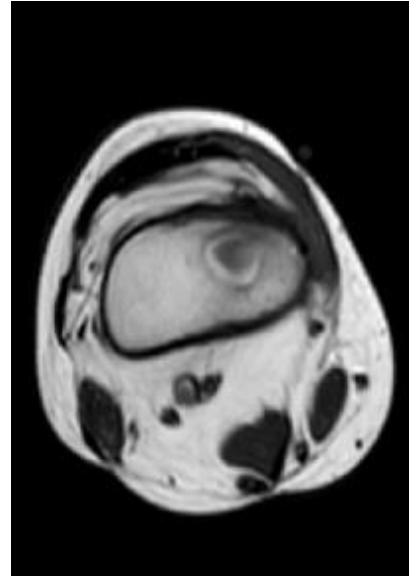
Axial image of MRI with contrast showing osteosarcoma in medial femoral cortex
